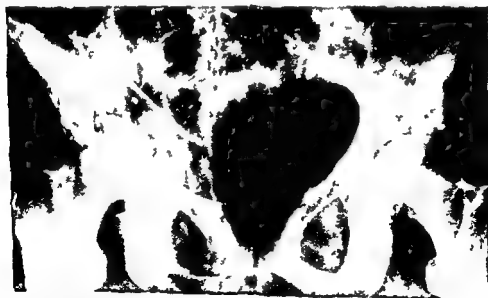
Radiograph of a central acetabular fracture with severe central dislocation of the femoral head where the superior dome is fractured in the right hip in a 59-year-old female
